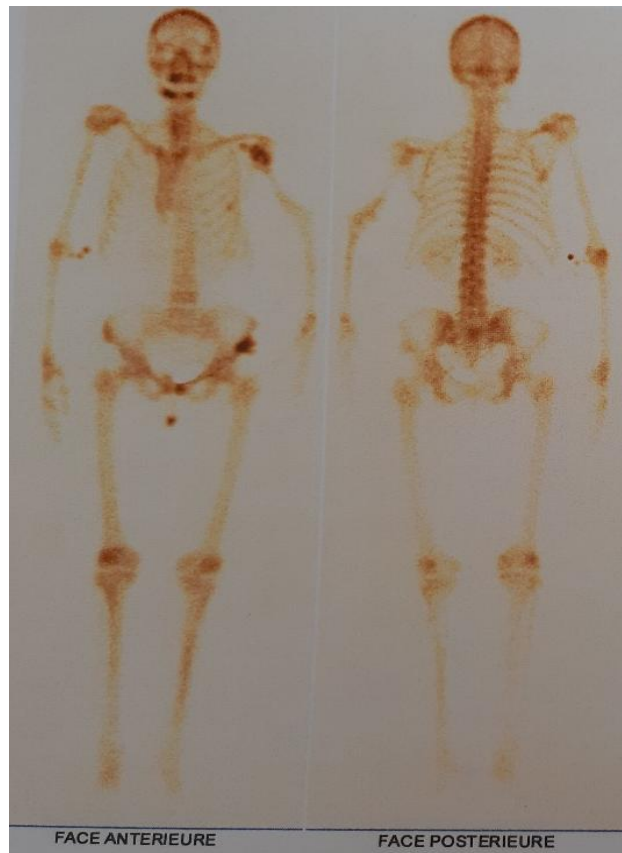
Bone scintigraphy, at 3 years of follow-up, noted hyperfixation at the proximal part between graft and proximal fragment
